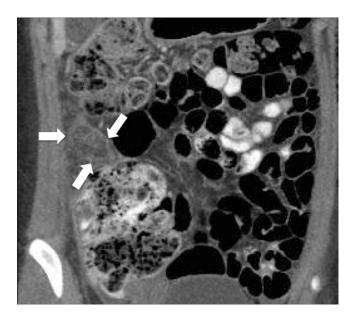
Coronal CT image with intravenous and enteric contrast shows a poorly defined fatty mass (*arrows*) within the right hemiabdomen with reticulation of the surrounding fat consistent with an omental infarction.
